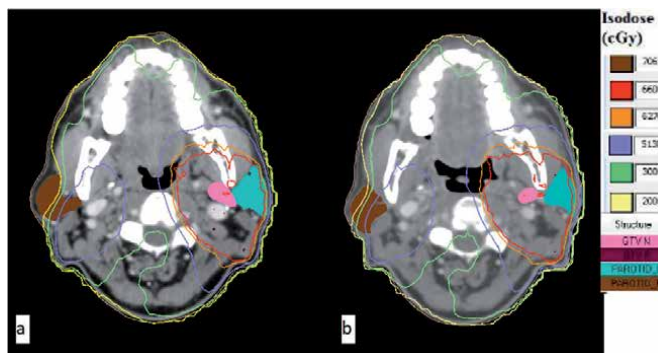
Comparison between pre-treatment (a) and per-treatment (b) images of a Patient undergoing IMRT-SIB. Coronal CT slices of a 55 years old male carcinoma pyriform fossa (T1N3b) patient. We can appreciate the decrease in GTV nodal (pink) volume by end of treatment along with decrease in volume of both right (brown) and left (light blue) parotid glands (b). The low dose isodose curves of 20 Gy (light yellow) and 30 Gy (light green) can be seen covering more areas of right parotid gland in (b) compared to (a).
